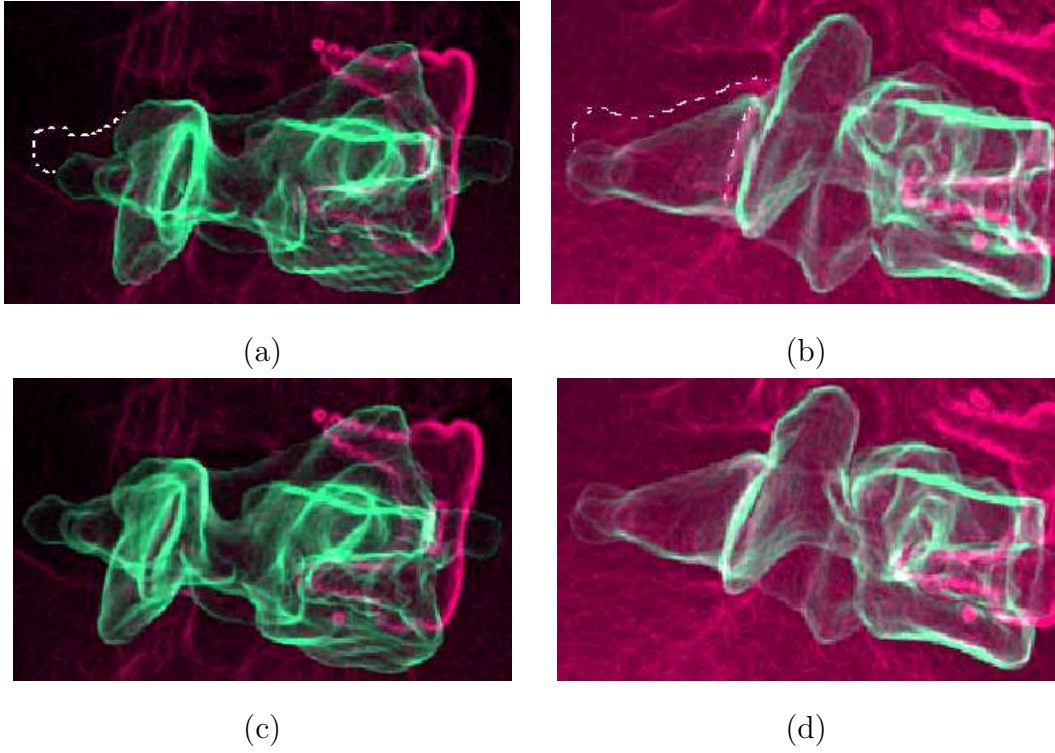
Comparison of tracking results between the single-bone method without operator assistance (top row) against the hierarchical approach without operator assistance (bottom row). In each row, the two camera views are shown, with the vertebra (green) superimposed on the X-ray image (red); dotted lines show the target location of the vertebra. Note the single-bone solution is off-track, while the hierarchical one is on target.
